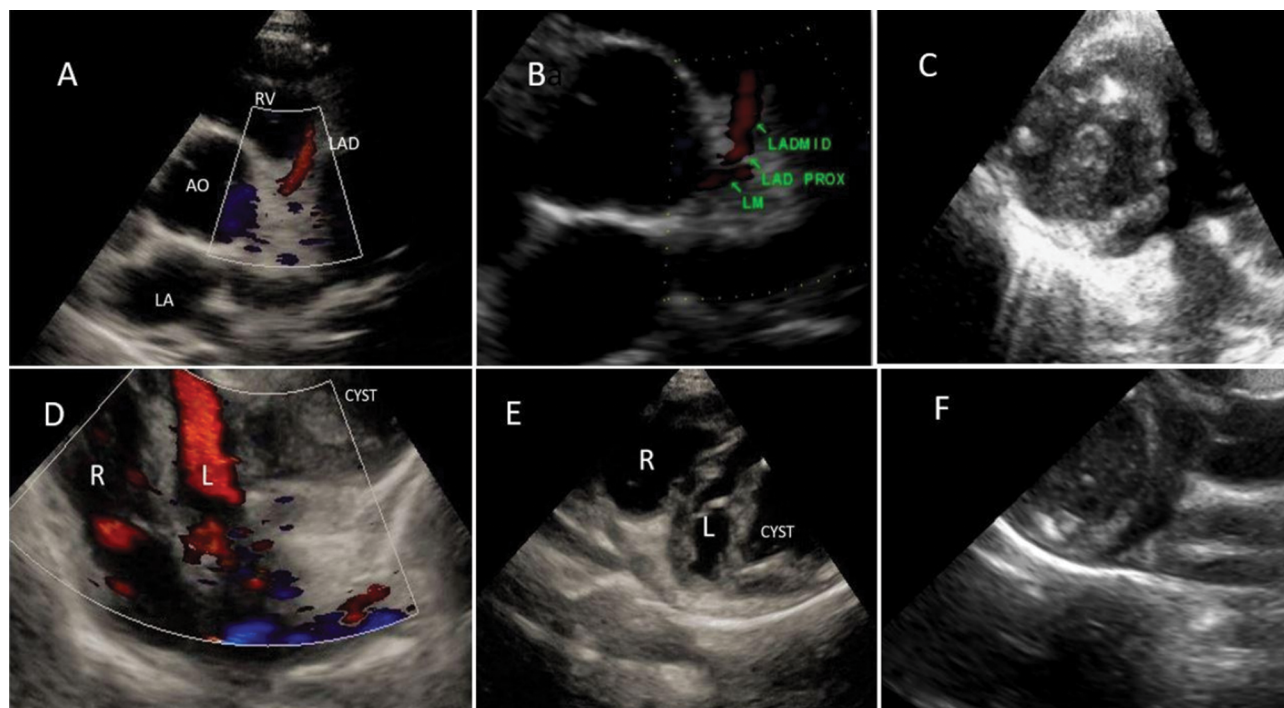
A, B. Left main and LAD coronary arteries; C. The cyst with calcinosis; D. A4C view; E. Short axis view; F. Parasternal view focused on the relation to the aortic valve.
